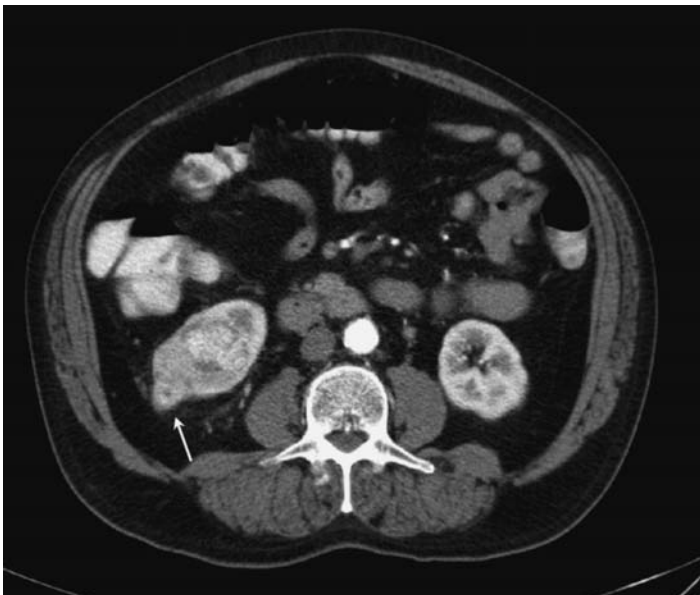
T3a Renal cancer. Contrast-enhanced CT demonstrates a right-sided lower pole renal tumor. Although small, it has an irregular lobulated contour extending into the perinephric fat (arrow). This was confirmed at surgery to be a T3a tumor.
